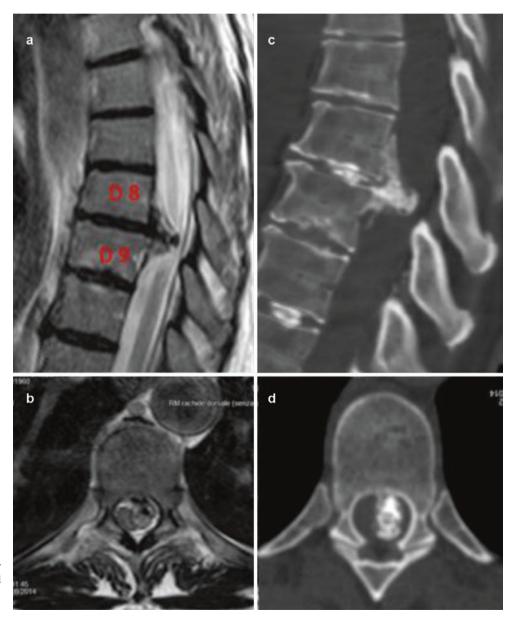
Case 1: preoperative magnetic resonance imaging (MRI) in sagittal (a) and axial
